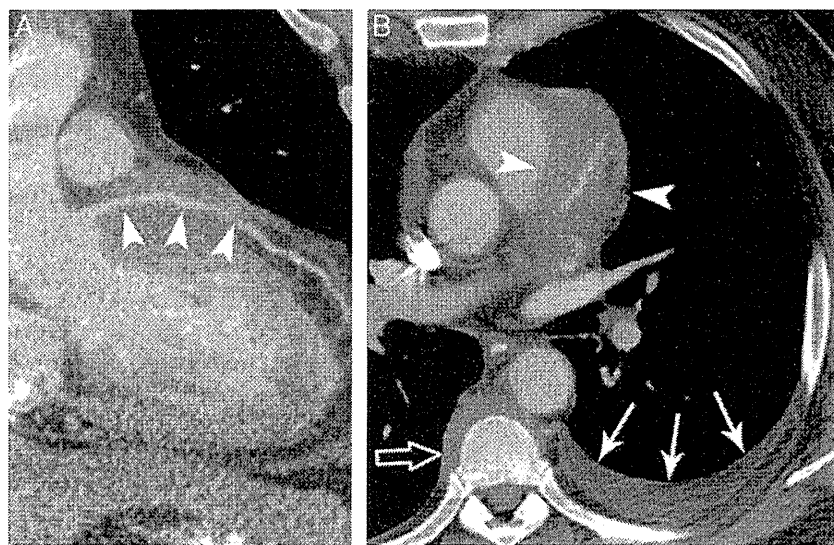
Contrast enhanced computed tomography of a case of idiopathic retroperitoneal fibrosis. (A) Abnormal soft tissue encasing normal diameter left main (white arrowheads) and proximal left anterior descending coronary arteries can be seen. (B) Axial image showing the abnormal soft tissue surrounding coronary arteries (white arrowheads), right paraspinal mass (open arrow), and left pleural effusion (white arrows). Reproduced from Maturen et al. [59].
